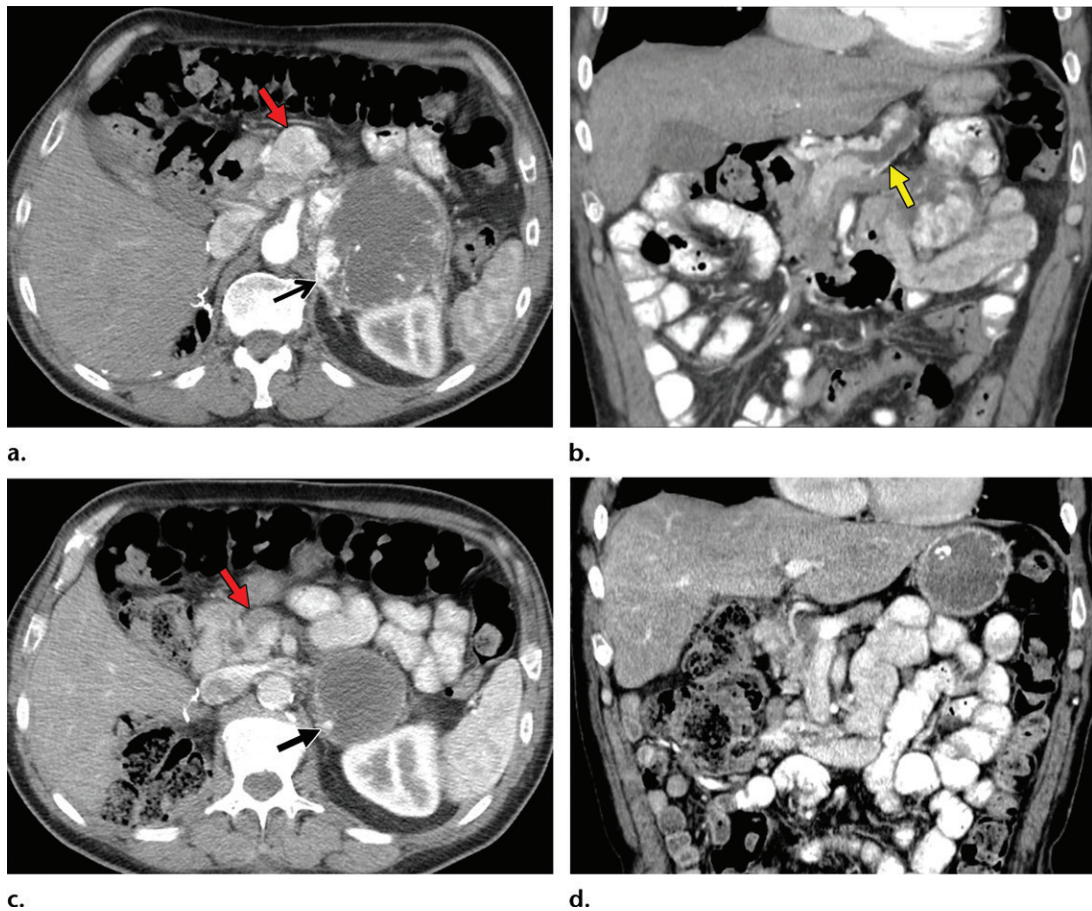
Metastatic RCC involving the pancreas and left adrenal gland in a 65-year-old man. (a, b) Axial (a) and coronal (b) contrast-enhanced CT images acquired during the arterial phase show an avidly enhancing mass in the pancreatic neck (red arrow in a) resulting in upstream dilation of the pancreatic duct (arrow in b). A large left adrenal metastasis (black arrow in a) is present. The patient was subsequently administered ipilimumab and nivolumab. (c, d) Axial (c) and coronal (d) contrast-enhanced CT images from an examination performed 3 months after the initiation of therapy show a dramatic decrease in the size and enhancement of the pancreatic (red arrow in c) and adrenal (black arrow in c) metastases. Note the associated resolution of pancreatic ductal dilation.
